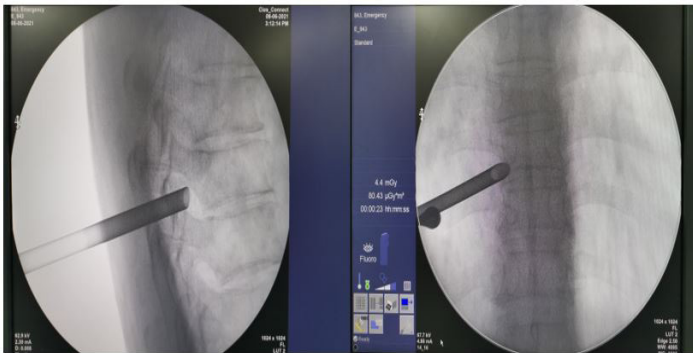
The final position of the dilating sheath is determined by the C-arm X-ray lateral view, which shows the distal end of the sheath located at the upper 1/3 of the intervertebral foramen, while the anteroposterior view demonstrates the distal end of the sheath positioned at the outer edge of the pedicle.
